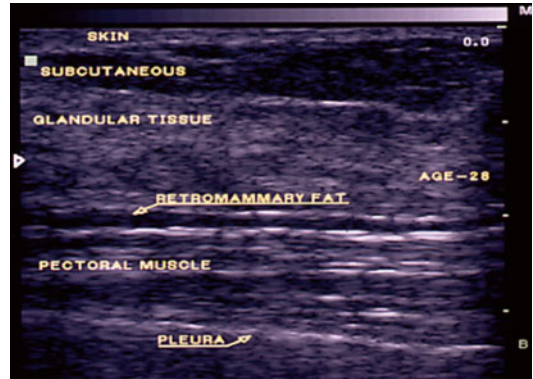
Normal ultrasound breast anatomy in a younger patient with dense breast parenchyma
